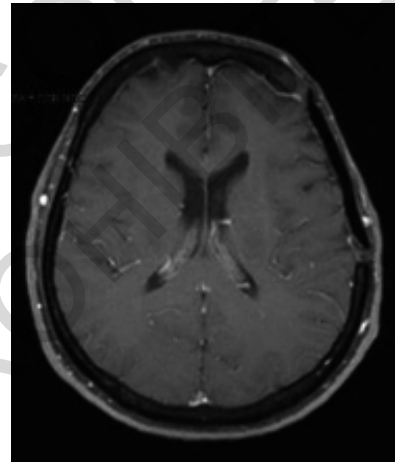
T1 post-operative MRI.
